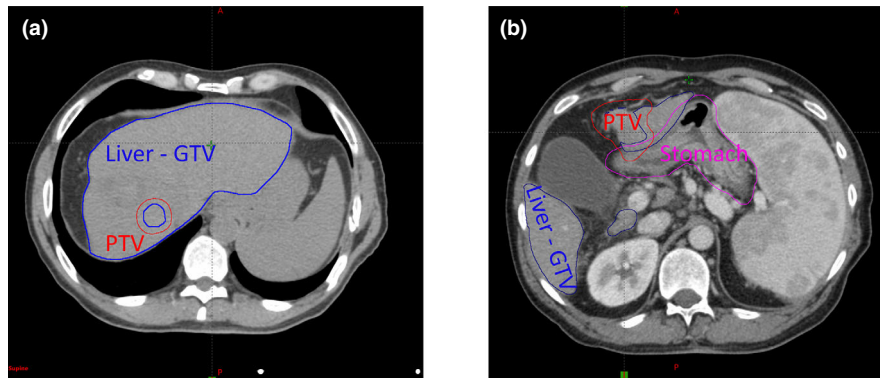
Computed tomography scans show contours for structures optimized for Case 1 (a) and Case 2 (b), respectively. Case 1 features a PTV that is roughly spherical in shape and far from major organs. (with the exception of the liver). Case 2 features a PTV with convex geometrical features and close proximity to both the liver and the stomach. PTV: planning target volume [Color figure can be viewed at wileyonlinelibrary.com]
